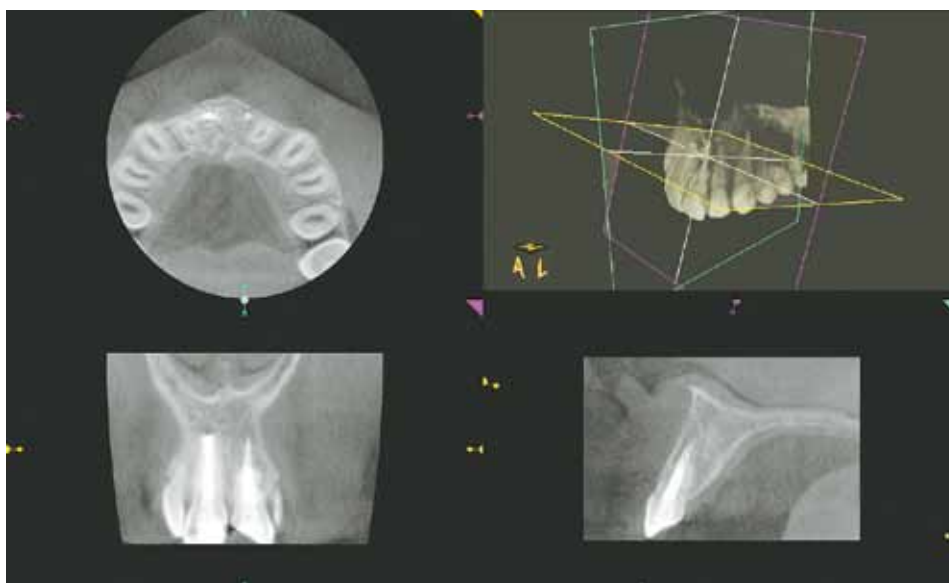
CBCT at the 1 year follow up.
